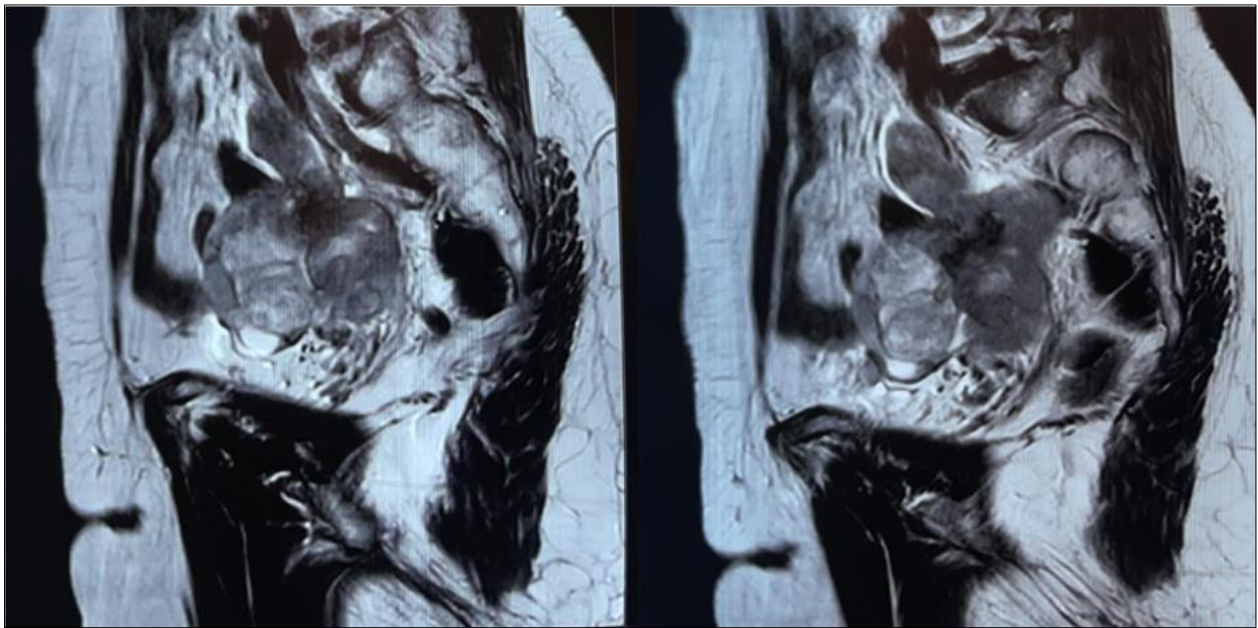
Axial T2 MRI images of the patient before treatment, showing the cervical tumor infiltrating the parametrium and bilateral adnexa
